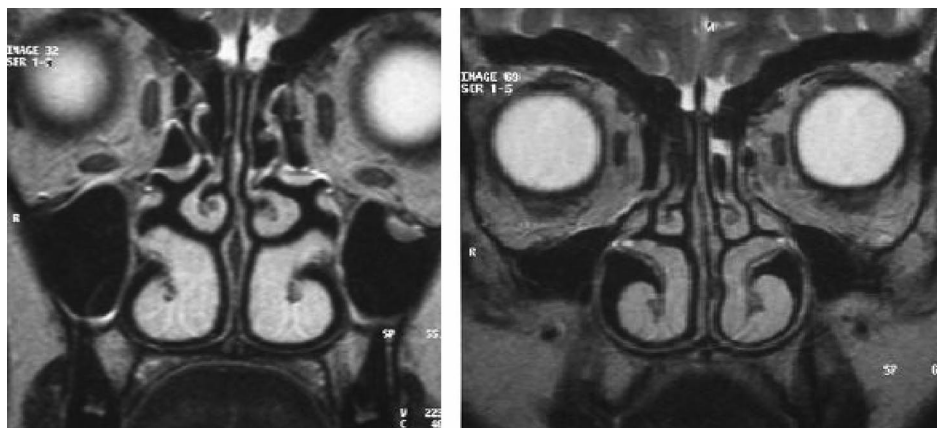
Magnetic resonance image of preoperative and postoperative coronal sections.
